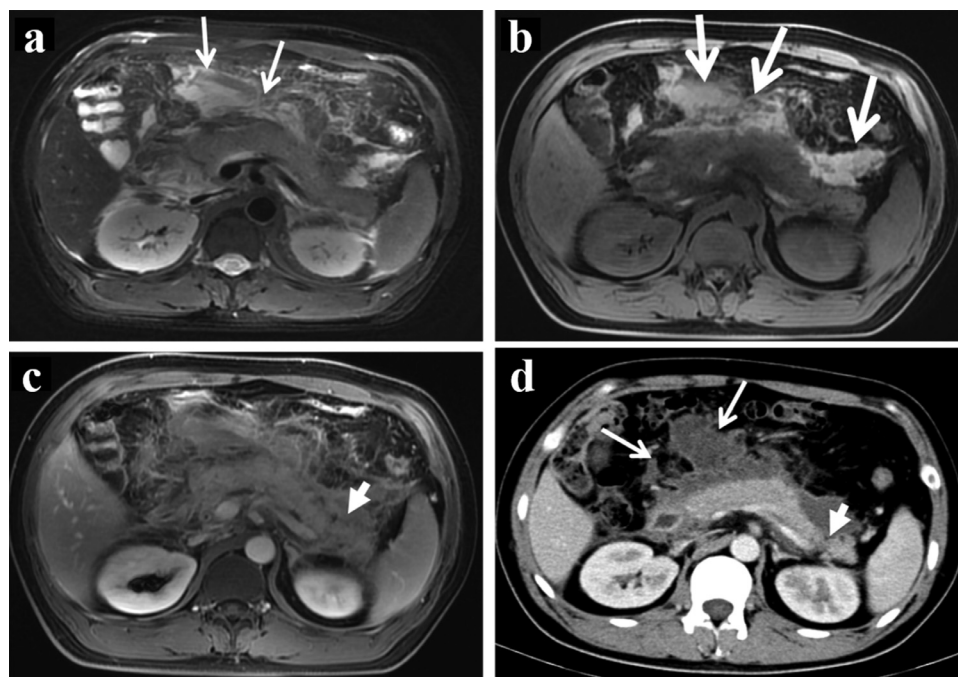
Combined necrosis in a 42-year-old man with extrapancreatic hemorrhage. (a–c) Axial T2-weighted MR image on the fifth day of onset show an evolving heterogeneous extrapancreatic collection around the neck, body, and tail of the pancreas involving the transverse mesocolon downward (white arrow). The extrapancreatic hyperintense signal on the axial fat-saturated T1-weighted MR image (thick white arrow) is suggestive of hemorrhage. A patchy hypointense region in the tail of the pancreas on the axial contrast-enhanced T1-weighted MR image (white arrowhead) demonstrates necrosis of the pancreatic parenchyma. (d) Axial contrast-enhanced CT imaging after 14 days shows a well-defined, heterogeneous extrapancreatic collection (white arrow), and a patchy hypoattenuating region in the tail of the pancreas (white arrowhead).
